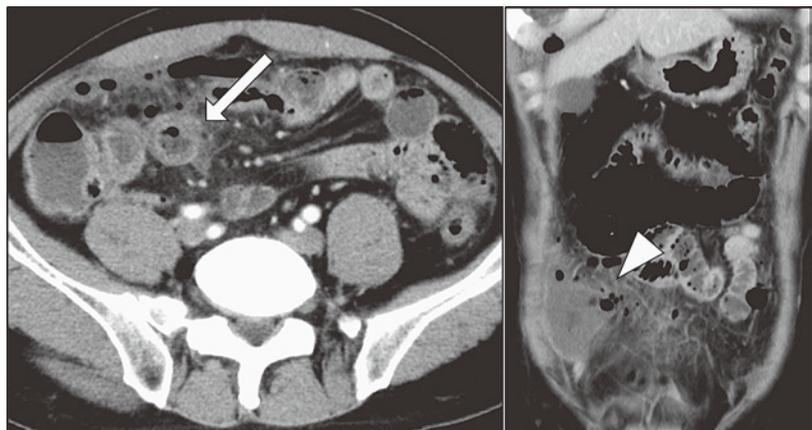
A : An X-ray examination of the chest showed free air (arrow) under the right side of the diaphragm. B : A second contrast-enhanced computed tomographic scan of the abdomen showed focal wall thickness and pneumatosis intestinalis in the jejunum (arrow) and abscess formation in the abdominal cavity (arrow head).
